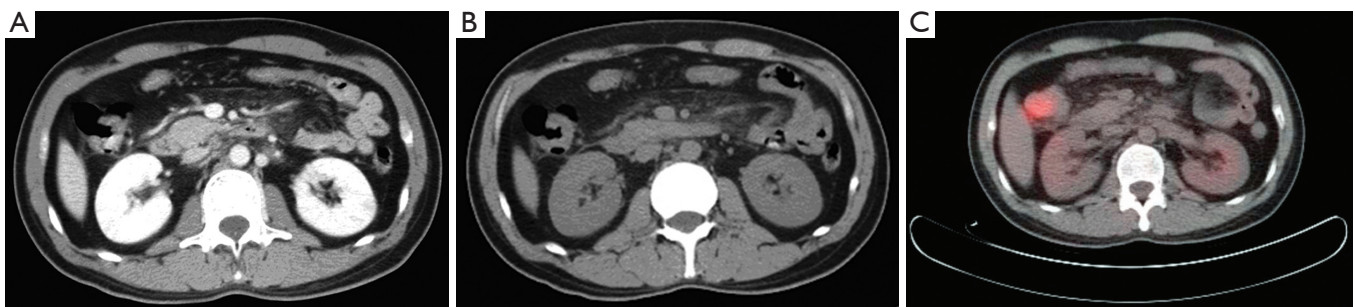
A large neoplasm is found in the ascending colon. A. CT enhancement scan; B. CT plain scan; C. PET/CT image (maximum SUV value is 8.09)
